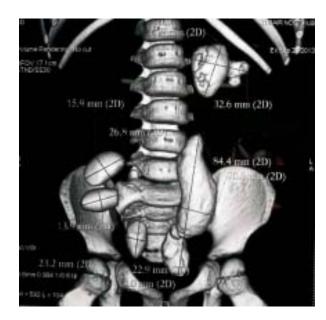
Non contrast computed tomography of kidney, ureter and bladder (NCCT KUB) with 3D reconstruction showing stones in both ureters and left pelvicalyceal system
